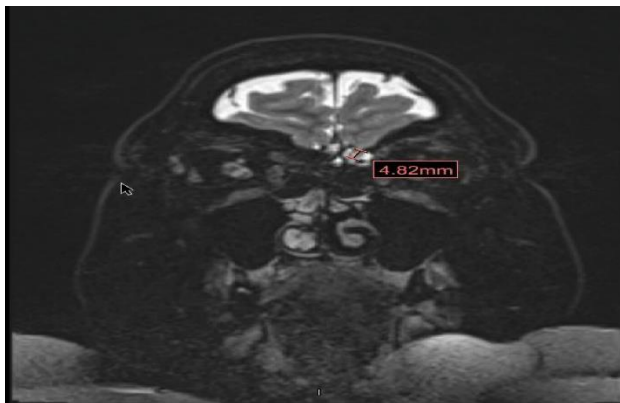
Coronal view of MRI brain showing a small left side anterior ethmoid cell roof defect and small brain tissue herniation measuring about 5 mm.
